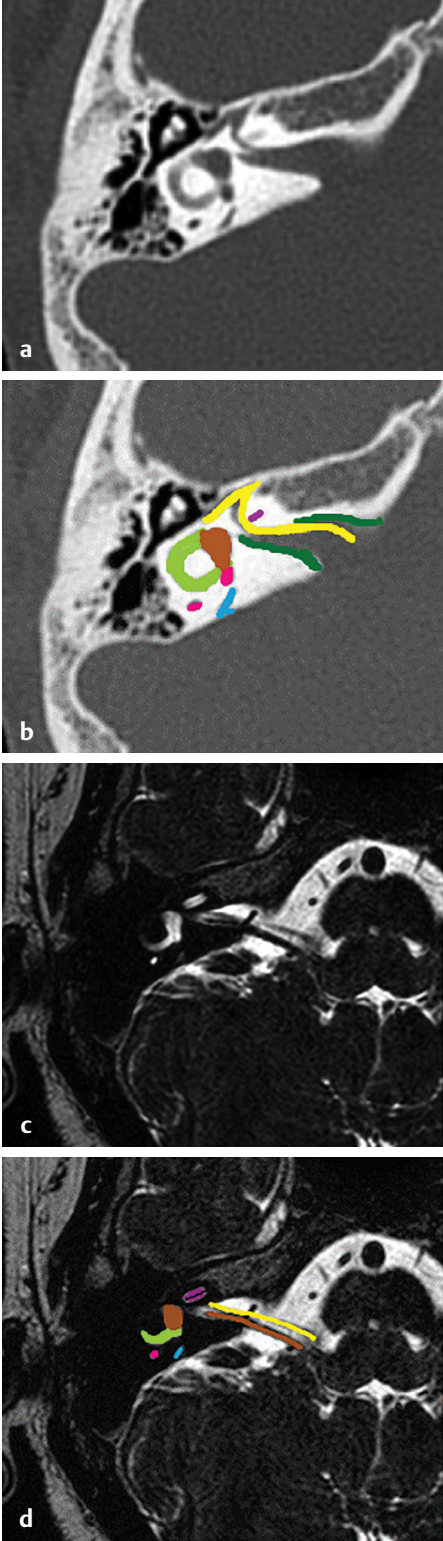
(a, b) HRCT temporal bone, axial section, bone window and (c, d) MRI CISS/FIESTA sequence, axial section show (pink) posterior semicircular canal (SCC), (yellow) meatal and labyrinthine segment of facial nerve, (dark pink) middle turn of cochlea, (brown) vestibule and superior vestibular nerve, (light green) lateral SCC, (blue) vestibular aqueduct, and (dark green) IAC.
